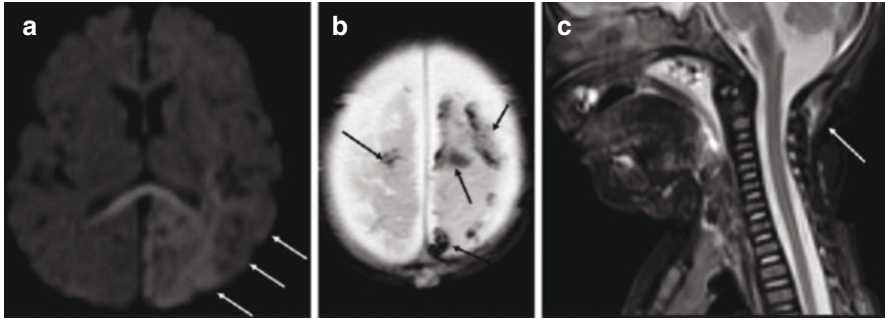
Typical brain and spine findings in a case of abusive head trauma. DWI of the brain (a) shows areas of acute ischaemia in the left parietal hemisphere (white arrows) and corpus callosum. Axial T2 gradient shows multiple subdural haematomas (black arrows in b). Sagittal T2 of the cervical spine with fat saturation shows ligamentous injury (white arrow in c)
